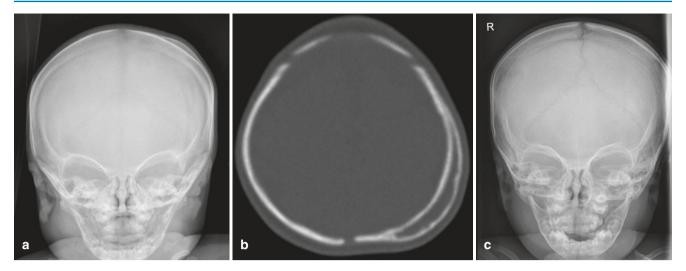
Calcifying cephalhaematoma. Skull radiograph (a) and CT (b) at the age of 3 months. At the age of 12 months (c) the calcified cephalhaematoma has almost resolved and blended with the cortical bone
